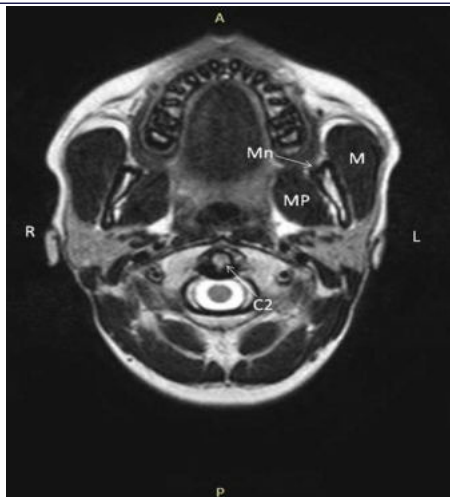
MRI SCAN OF HEAD REGION (T2 – AXIAL IMAGE)
